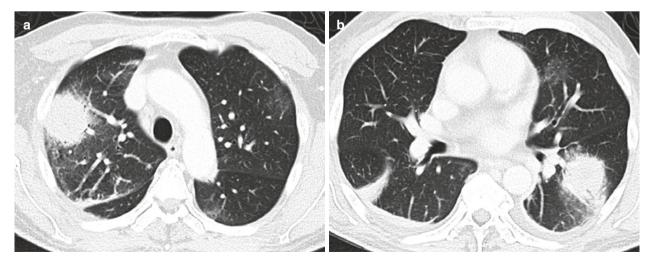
A 55-year-old man with septic pulmonary embolism and UTI. (a, b) Axial CT images show large consolidations with surrounding "halo" of ground-glass opacities
